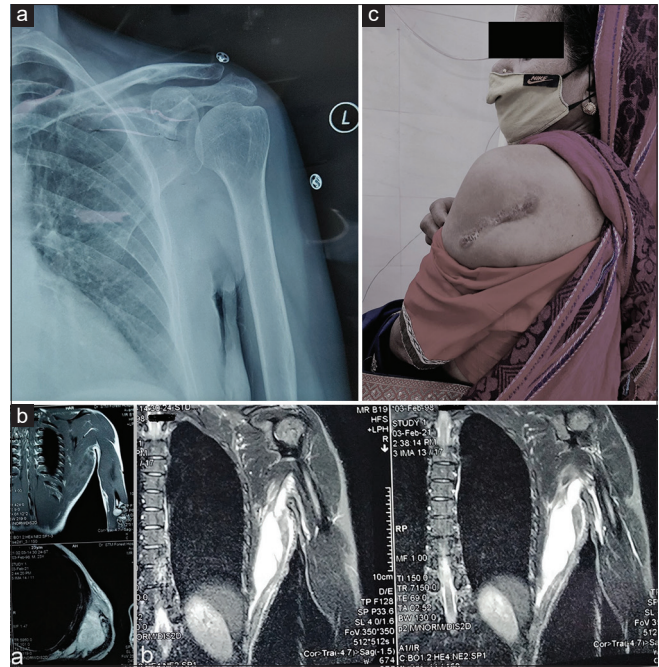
The radiograph showing normal osteoarticular status (a) and MRI images showing lower scapula collection extending into lateral chest wall and axilla (b). The healed incision given over the prominent area of swelling with no recurrence of the disease (c)
